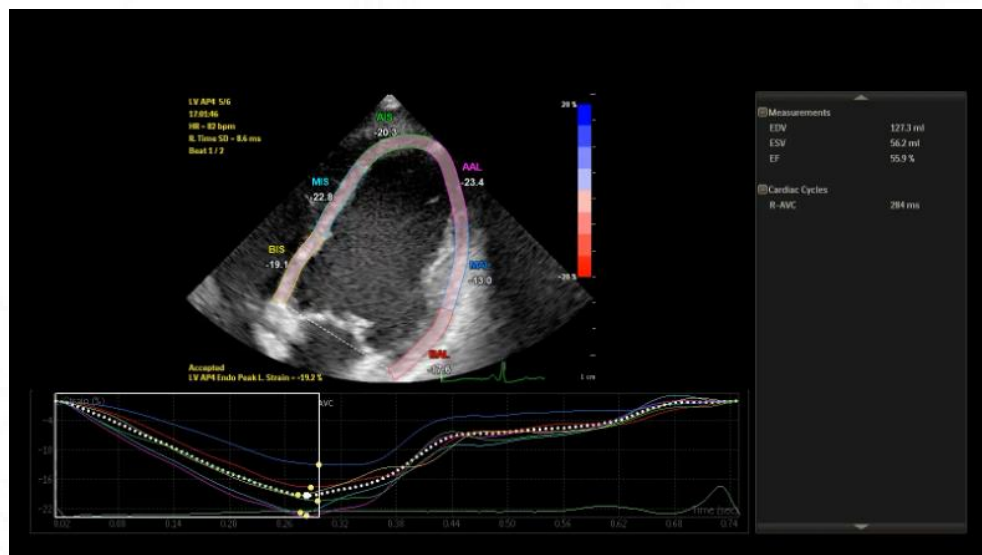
11: Acquiring 2D images in apical 4,3,2 chamber views and Basal, mid, and apical short axis views.
